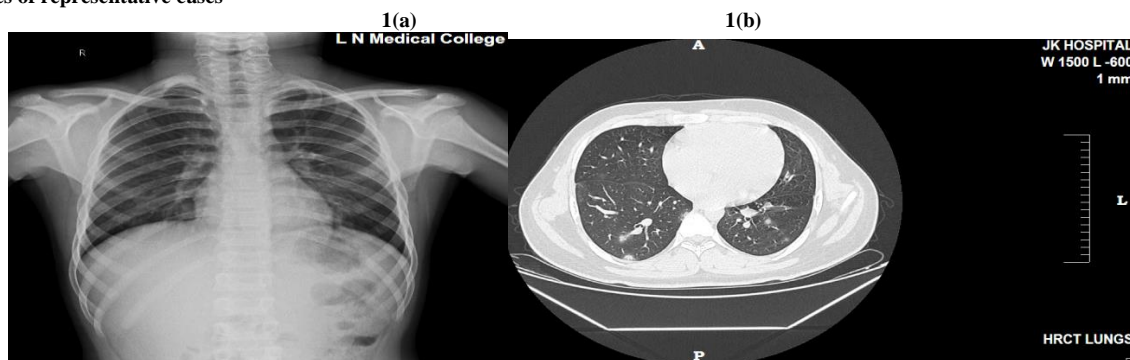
(a)-Chest radiograph of 12yrs old RTPCR positive patient showing normal findings. 1(b)-HRCT of same patient showing multiple discrete patches of GGO seen in both lower lobes. CT severity score; 5 (Mild lung involvement).
